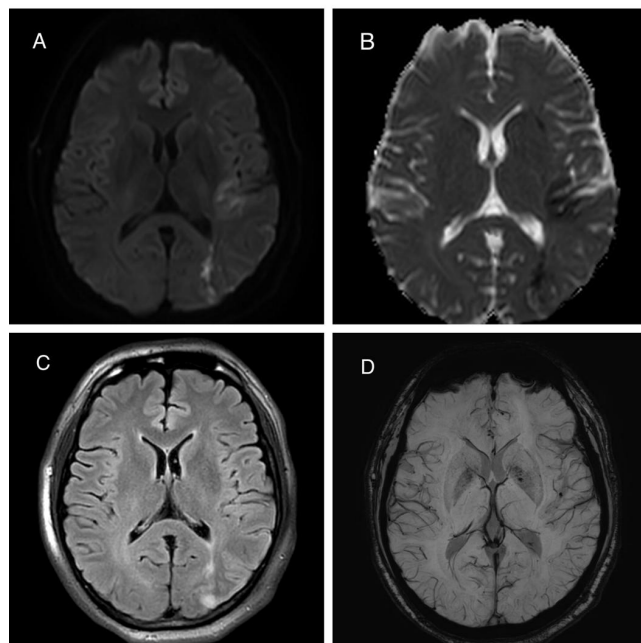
A-B: Showing diffusion weighted imaging (DWI) (Figure-1A) and the apparent diffusion coefficient (ADC) (Figure-1B) map showing acute infarct at the left temporo-parietal region, corresponding to the left middle cerebral artery (MCA) territory, likely due to a distal vessel occlusion (DVO). C: No matched high signal intensity is noted on the fluid attenuated inversion recovery (FLAIR) sequence. D: No blooming is seen on the susceptibility weighted imaging (SWI) sequence to suggest hemorrhage.
